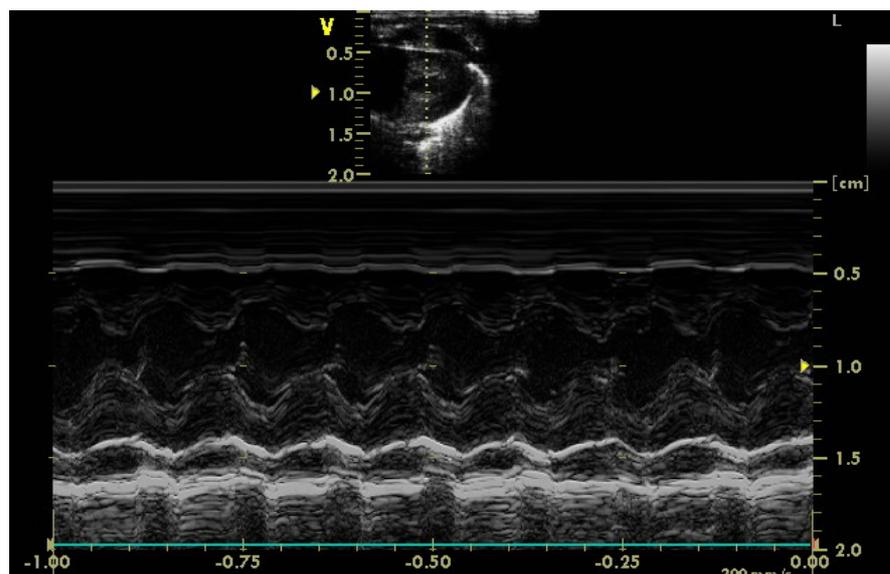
Parasternal short axis view for measuring ventricular width in systole and diastole. Measurements are taken at the origin of the papillary muscles at end systole and end diastole.
